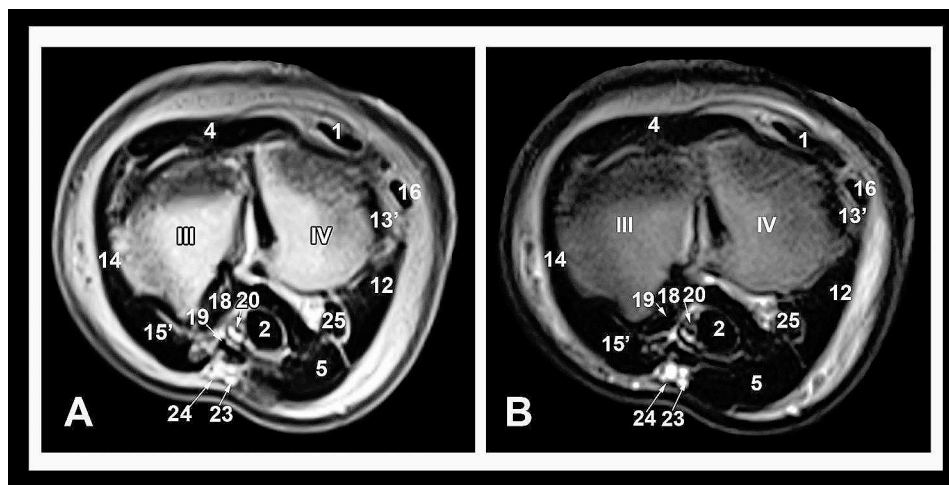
Transverse T1 (A) and PD-weighted (B) high-field MRI images at the level of the proximal metacarpal region. Medial is to the left. III, 3rd metacarpal bone; VI, 4th metacarpal bone; 1, common digital extensor tendon; 2, deep digital flexor tendon; 4, radial carpal extensor tendon; 5, superficial digital flexor tendon; 12, long lateral collateral carpal ligament; 13', distal part of the short lateral collateral carpal ligament; 14, long medial collateral carpal ligament; 15', distal part of the short medial collateral carpal ligament; 16, lateral digital extensor tendon; 18, radial carpal flexor tendon; 19, median artery; 20, median vein; 23, radial artery; 24, radial vein; 25, accessoriometacarpal ligament
